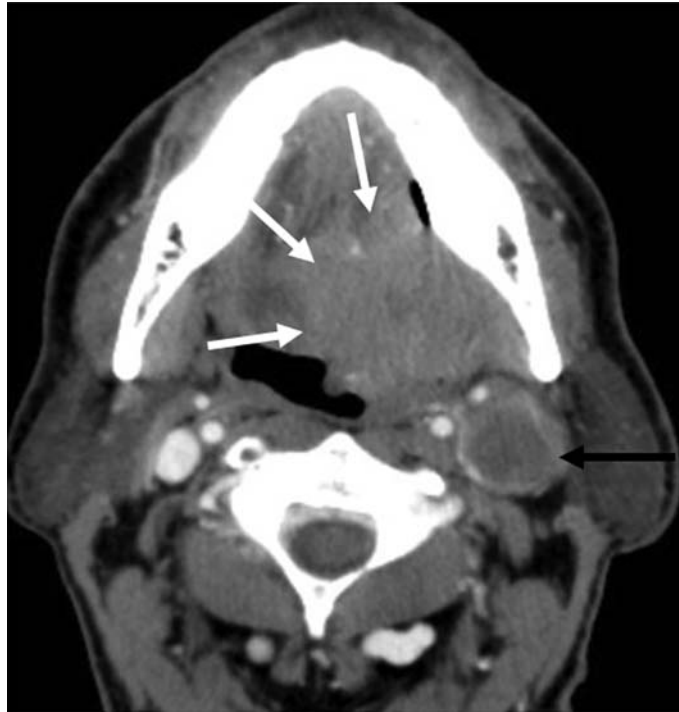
Contrast-enhanced CT axial image in a 55-year-old male smoker with squamous cell carcinoma of the tongue demonstrates an enhancing soft tissue mass involving the left oral tongue (*white arrows*) with extension to the midline. There is also a large necrotic-appearing left level 2 lymph node (*black arrow*) consistent with nodal metastasis. From Meesa, I. R., Srinivasan, A. (2015). Imaging of the oral cavity. *Radiologic Clinics of North America* 53(1), 99–114.
